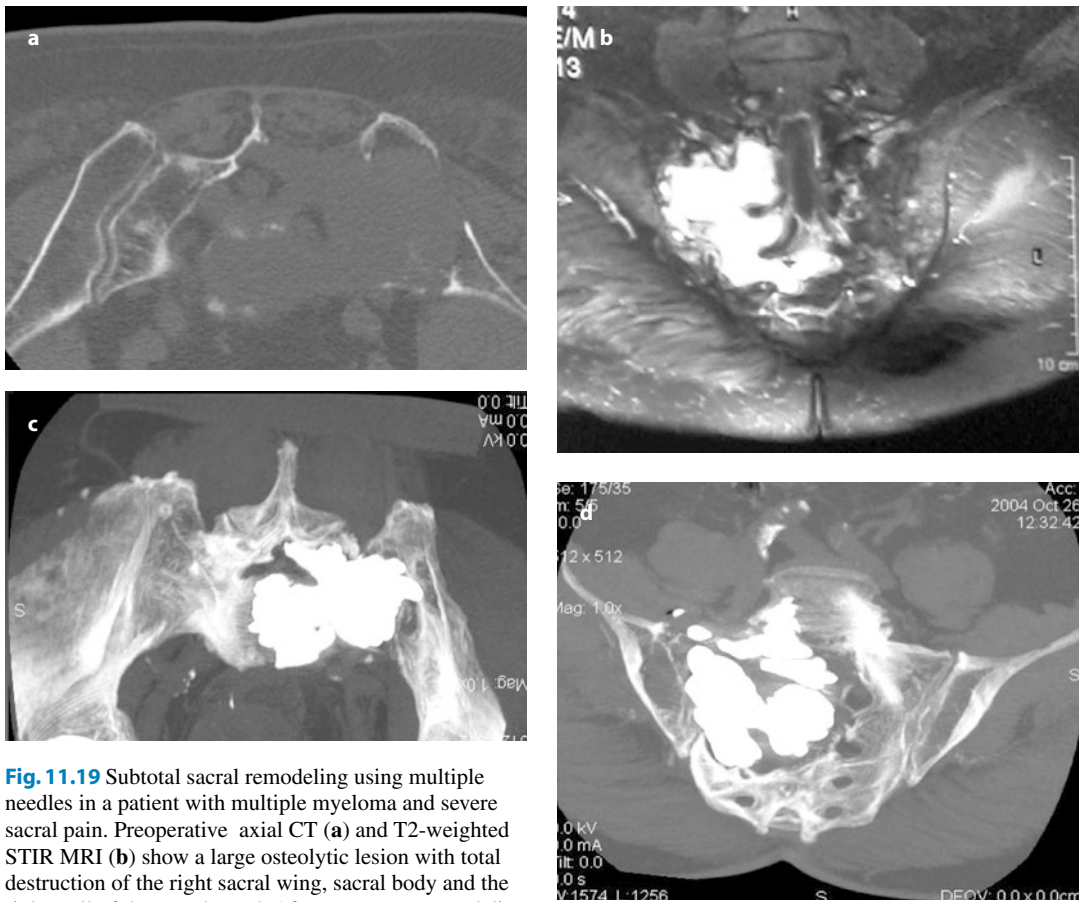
Subtotal sacral remodeling using multiple needles in a patient with multiple myeloma and severe sacral pain. Preoperative axial CT (a) and T2-weighted STIR MRI (b) show a large osteolytic lesion with total destruction of the right sacral wing, sacral body and the right wall of the sacral canal. After treatment, remodeling of the sacral wing and posterior wall of the sacral canal can be observed, with remodeling the right first and second sacral foramina and with no leakage into the sacral canal (c and d)
